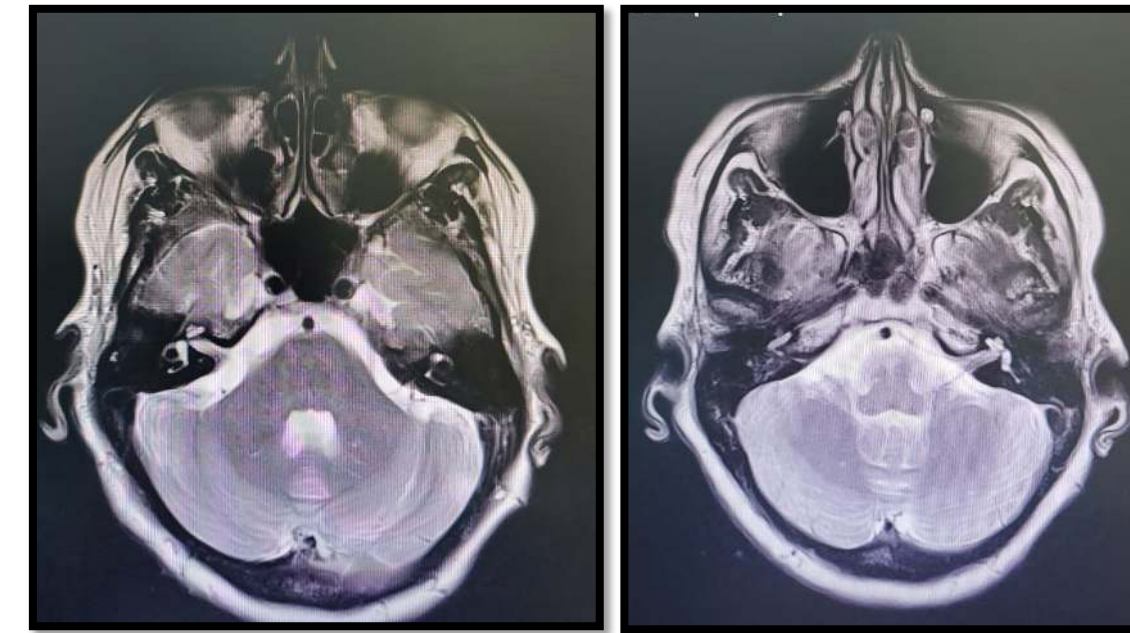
MRI IAM showing bilateral vascular loop
